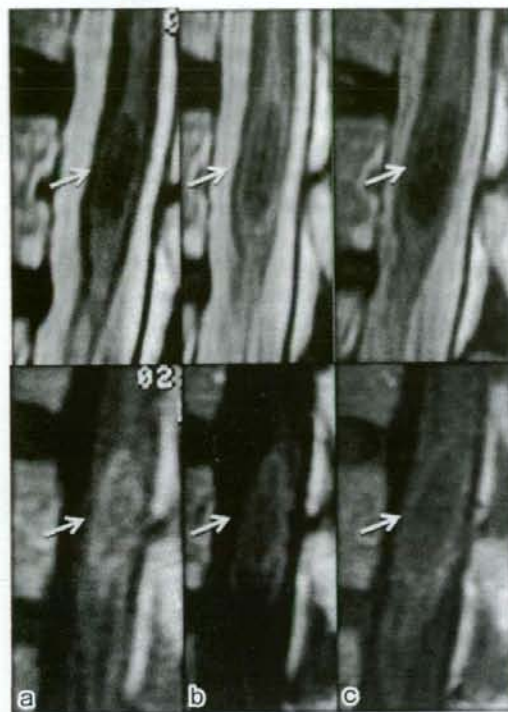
Follow-up T2-weighted (upper) and gadolinium-enhanced T1-weighted (lower) MRI scan of the lumbosacral regions. Sagittal T2-weighted image taken 7 days after admission shows hyperintensity on surrounding of low intensity lesion (b) despite of no hyperintensity on admission (a). MRI without and with gadolinium taken 30 days after admission no longer shows any hyperintense lesions in T2-weighted image and any surrounding enhancement (c).
